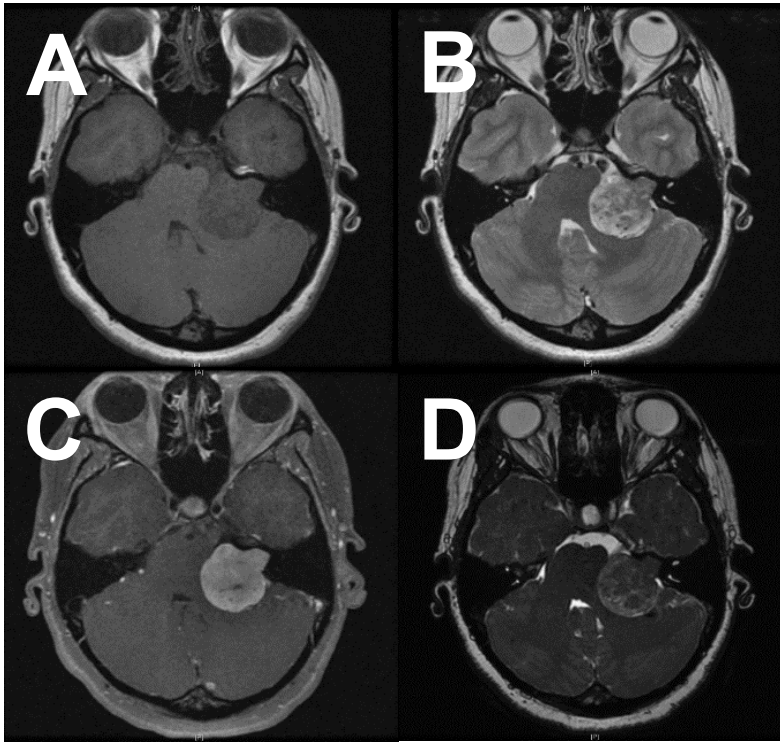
Preoperative axial MRI showing left acoustic neuroma. A: T1-weighted MRI, tumor is hypointense. B: T2-weighted MRI, tumor is hyper- and hypointense. C: Post-gadolinium T1-weighted MRI, tumor is enhancing and hyperintense. D: FIESTA MRI, tumor hyper- and hypointense.
